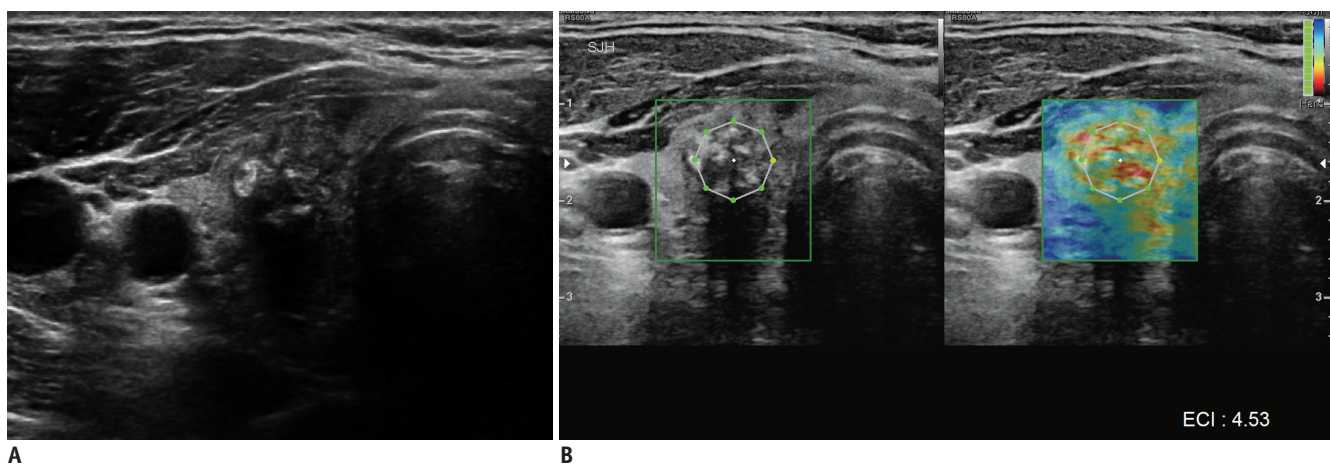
Gray-scale US (A) and elastography (B) of malignant thyroid nodule. Gray-scale US images (A) show solid hypoechoic nodule with spiculated margins and calcifications in right lobe of thyroid gland. This nodule was classified as K-TIRADS category 5. At elastography evaluation (B), this nodule presents stiff pattern (red) in elastography ROI (green box) and high elasticity contrast index (4.53) calculated from ROI (white octagon). This nodule was confirmed as papillary thyroid carcinoma after surgery. ECI = elasticity contrast index, K-TIRADS = Korean Thyroid Imaging Reporting and Data System, ROI = region of interest, US = ultrasonography
